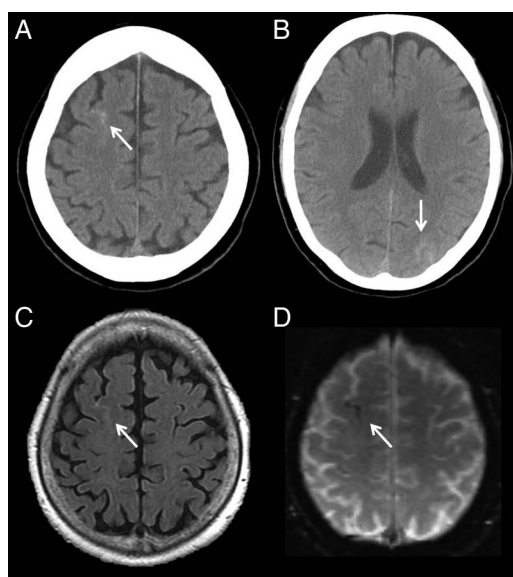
(A and B) CT of the head reveals a mild cortical subarachnoid haemorrhage (cSAH) in the right frontal and left temporal lesion (arrow). (C and D) Brain MRI on admission shows high-intensity changes for cSAH on fluid-attenuated inversion recovery imaging and low-intensity changes on gradient echo T2*-weighted imaging (arrow).
